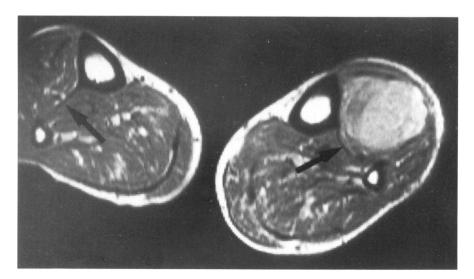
MRI done with T2 weighting (SE TR=1500, TE=30) clearly demonstrates the interosseous septum displaced posteriorly, but not transgressed (arrow), thus demonstrating that the pathology is limited to the anterior compartment.
